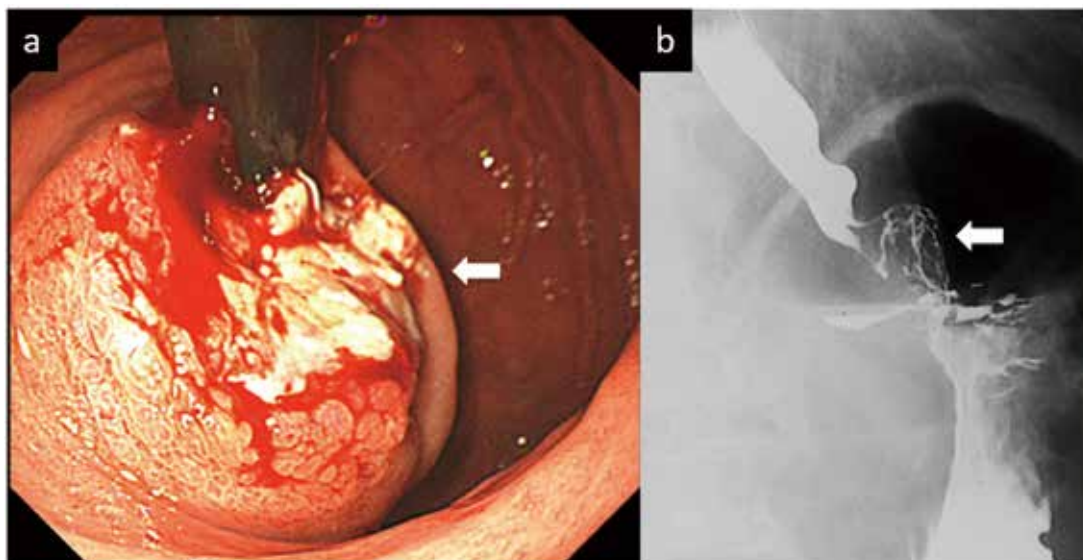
Esophagogastroduodenoscopy (a) and upper gastrointestinal contrast radiography (b) showing an ulcerative tumor (arrows) in the abdominal esophagus exposing the cardia
